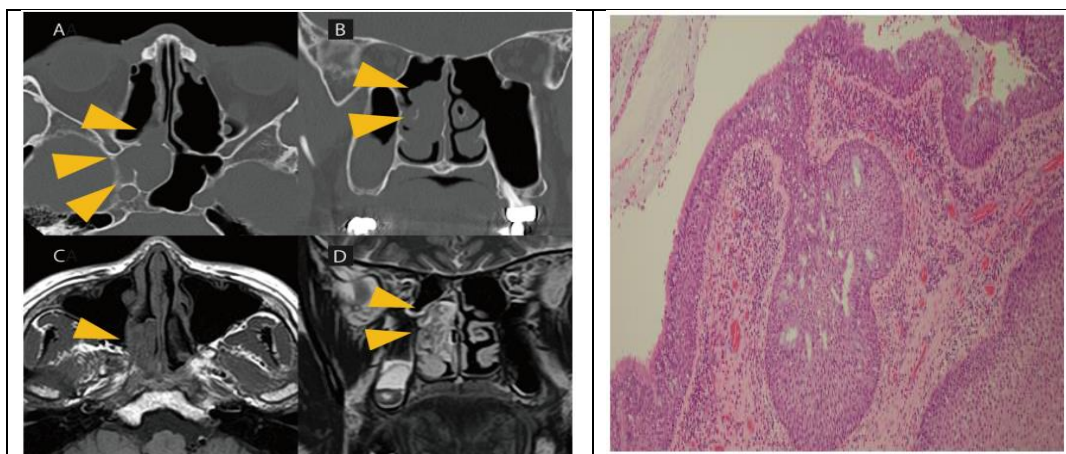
(A, B) Axial computed tomography (CT) of the paranasal sinuses; (C, D) Magnetic resonance imaging (MRI) of the sinuses. Yellow triangles indicate the tumor on both imaging modalities.
